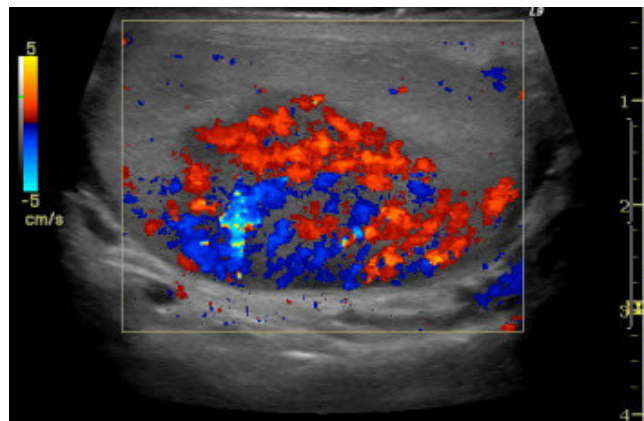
51 year old male with diffuse large B-cell non-Hodgkin's lymphoma. Sagittal ultrasound using 9 MHz linear GE transducer of the right testicle performed 11 months after initial chest CT with color Doppler at the same level showing the hypervascular nature of the hypoechoic mass in the posterior aspect of the right testicle.
